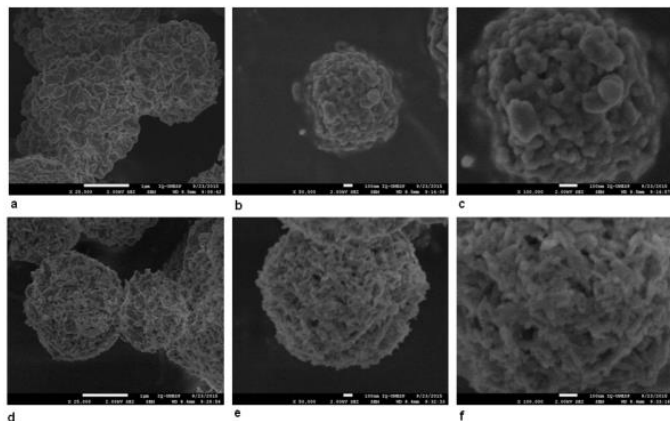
Results of analysis by SEM. ACP synthesized without ultrasound (a: 25000X; b: 50000X and c: 100000X). ACP synthesized with ultrasound (d: 25000X; e: 50000X and f: 100000X).
